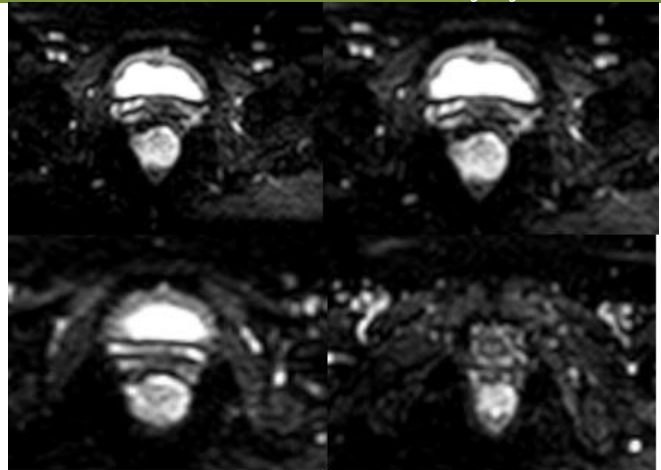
(A-D) Axial DWI images show an irregular mass lesion with restricted diffusion occupying the anorectal junction.
